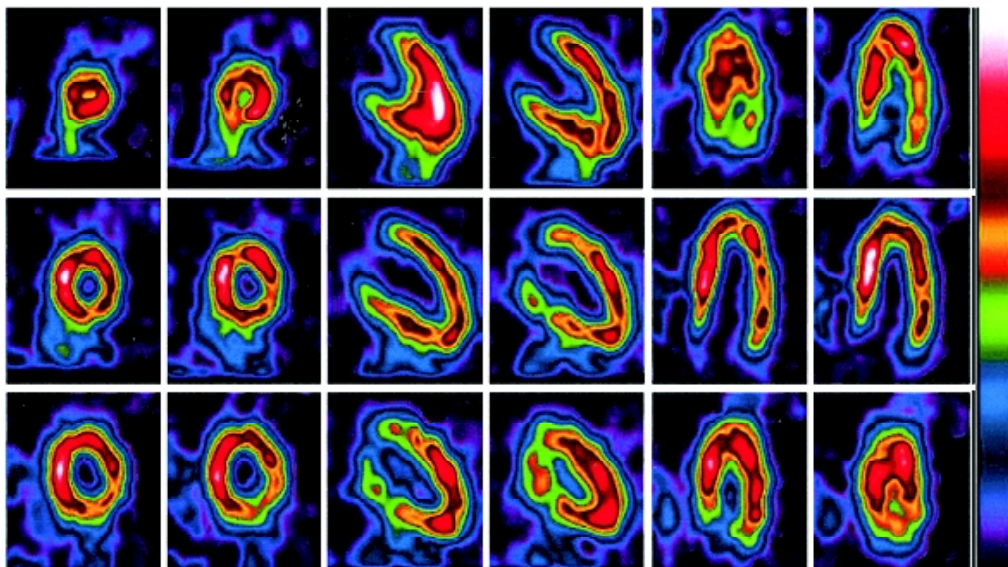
The SPECT $^{99}\text{Tc}^{\text{m}}$ -MIBI myocardial perfusion scan detected low perfusion (yellow color) in basal anterior wall, anterior wall and posterior wall of left ventricle. The brightness of color reflected the extent of myocardial perfusion
